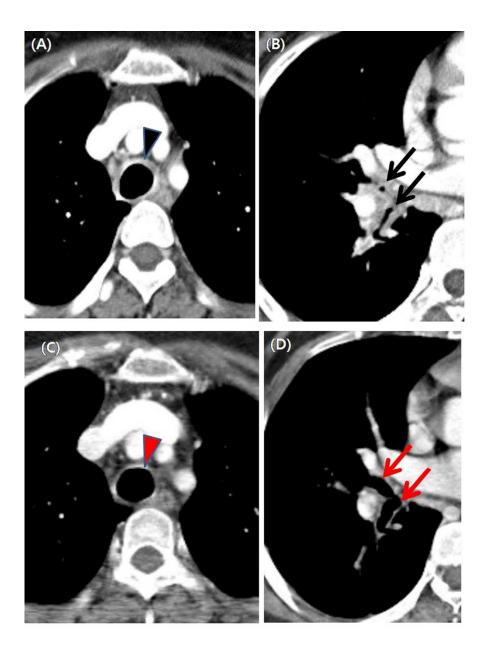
Chest computed tomographic images at baseline and at 3 months after treatment initiation
